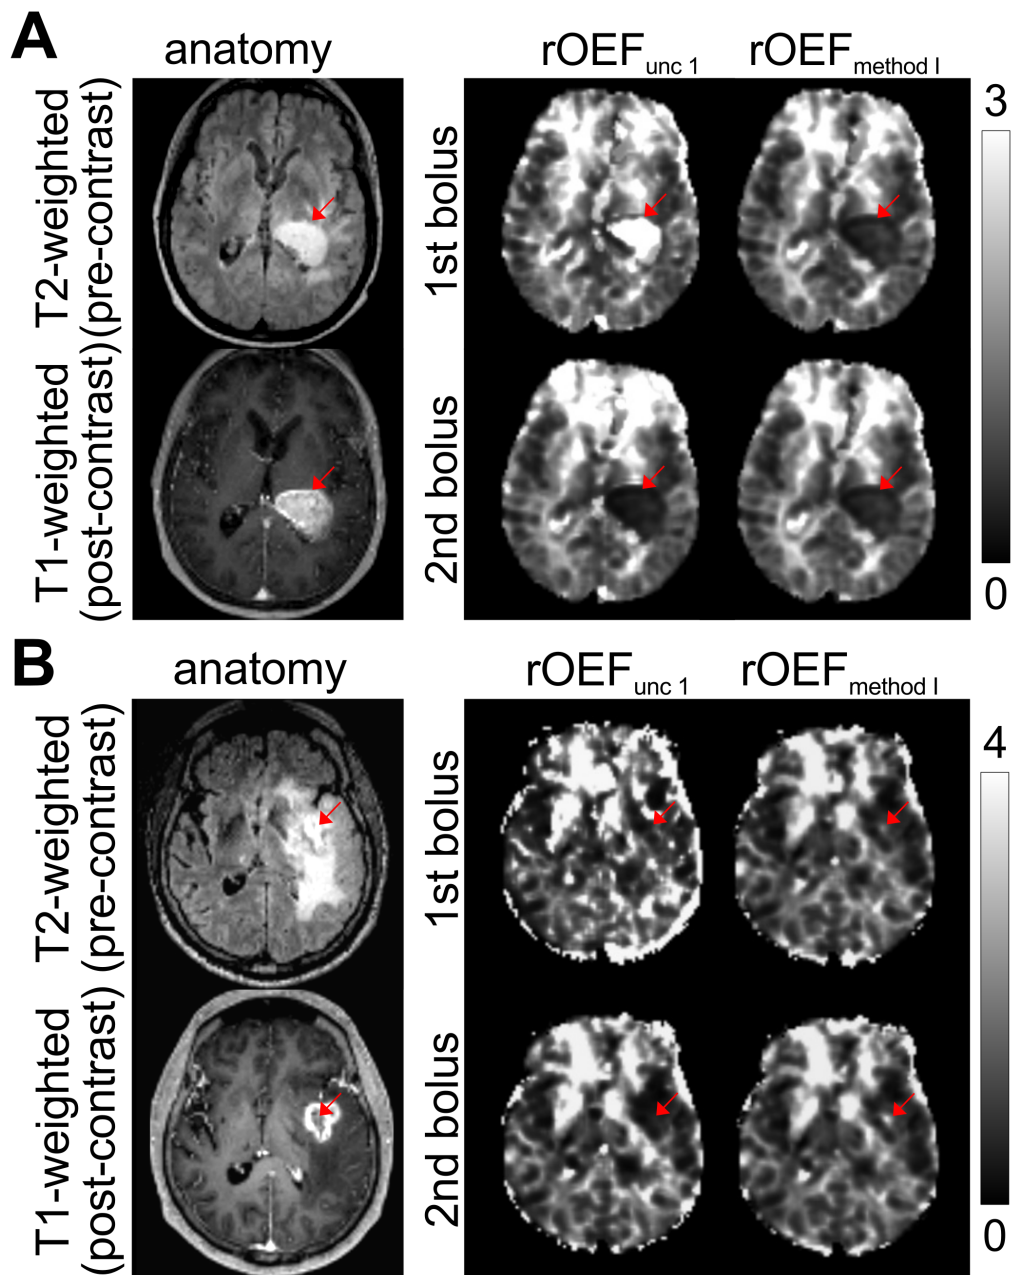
Influence of rCBV variation on rOEF parameter maps for one image slice of two patient examples. The left column shows anatomical images for each patient (A and B): a T2-weighted FLAIR (top) and a contrast enhanced T1-weighted MPRAGE (bottom). For the corresponding slice, rOEF was calculated with four different normalized CBV parameter maps: $nCBV_{unc\ 1}$ and $nCBV_{method\ I}$ each for the first and second bolus acquisition. Red arrows indicate differences due to leakage correction: the more visible, dark-rimmed CET structure for patient A and a newly appearing rOEF hotspot in patient B.
